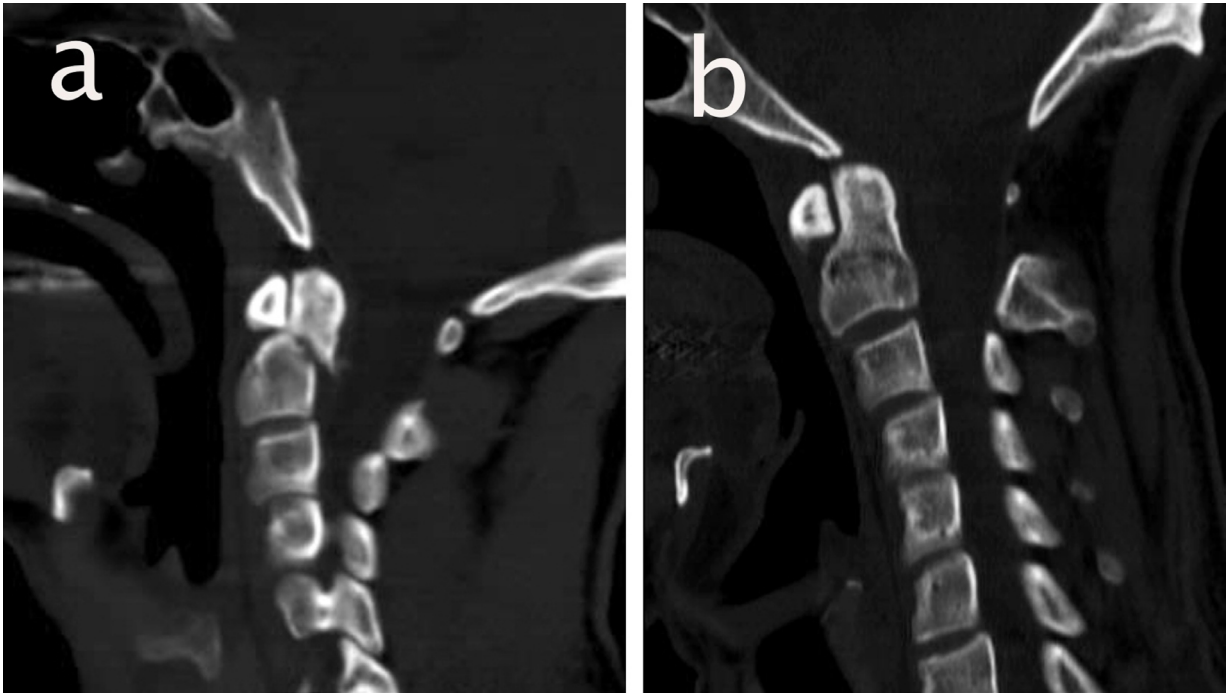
a) Posteriorly displaced type II odontoid fracture on sagittal cervical CT scan, b) CT sagittal view shows odontoid union at 8 weeks after Minerva CTJ application.
